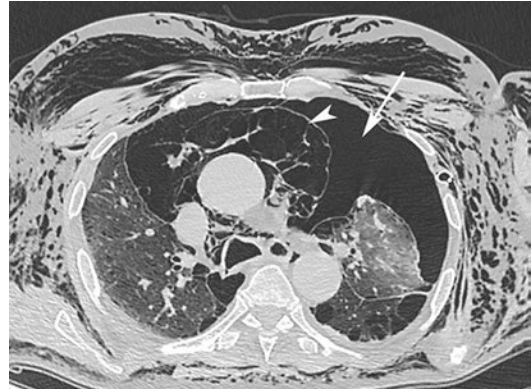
Post-contrast axial CT scan evidences a diffuse subcutaneous chest cage emphysema associated with a large pneumo-mediastinum (white arrow head) and left pneumothorax (white arrow) due to air leak
